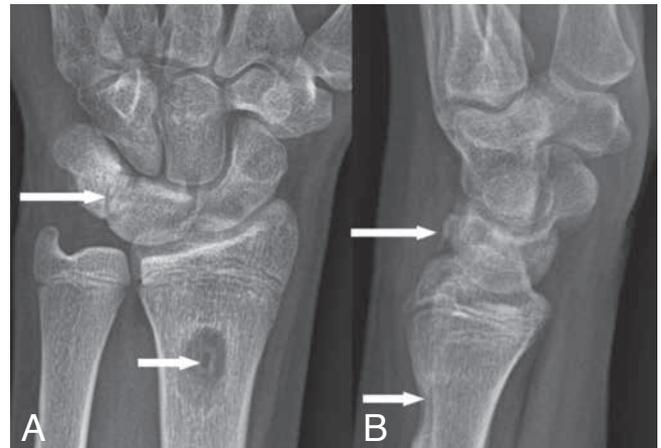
Surgical treatment of a symptomatic LTC (patient 3). Plain radiography. A corticocancellous wedge from the dorsal side of the distal radius (short arrows) was interposed between the lunate and triquetral bone (long arrows) after resection of the pseudarthrosis.
